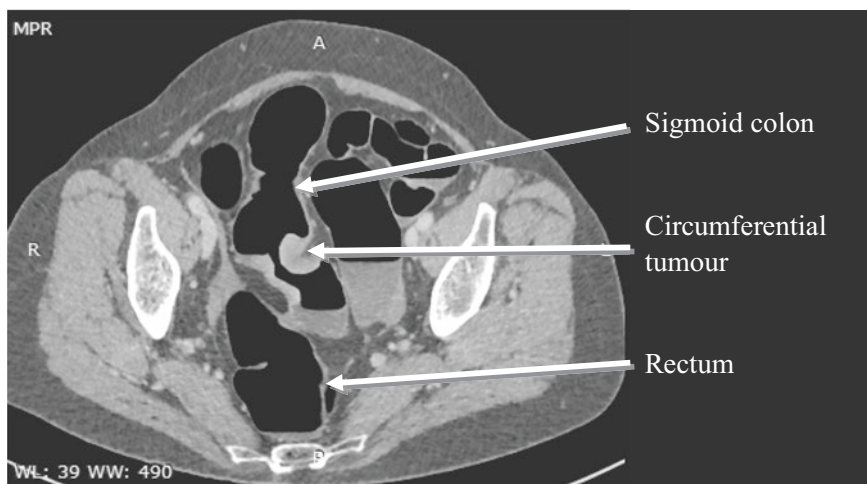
A 68 year old man was referred with intermittent blood per rectum for CT colonography. Axial contrast-enhanced image through the mid-pelvis demonstrates a tumour in the sigmoid colon with circumferential mural thickening and narrowing of the bowel lumen. This corresponds to the 'Apple-core' appearance classically seen on barium enema, a study which has been replaced by colonoscopy and CT colonography
